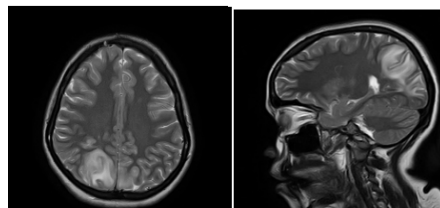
Case of 26yr old postpartum patient presented with headache. Both axial and sagittal section of ADC and T2 sequences of MRI, lesions appear as iso-intense or low signal intensity on T1-weighted images, and high signal intensity on T2-weighted images.
